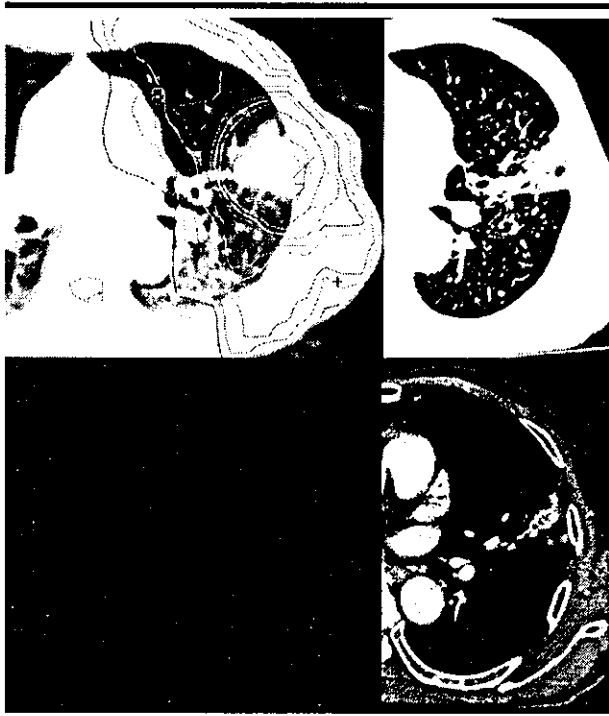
Transverse CT images show a representative case of wedge-shaped radiation-induced pulmonary injury. Left: Image obtained for treatment planning at the isocenter. Right and bottom: Images obtained 5 months after SRT. Wedge-shaped discrete consolidation involving the hilar and peripheral side of the tumor was observed. This shadow did not conform to any isodose curves.
